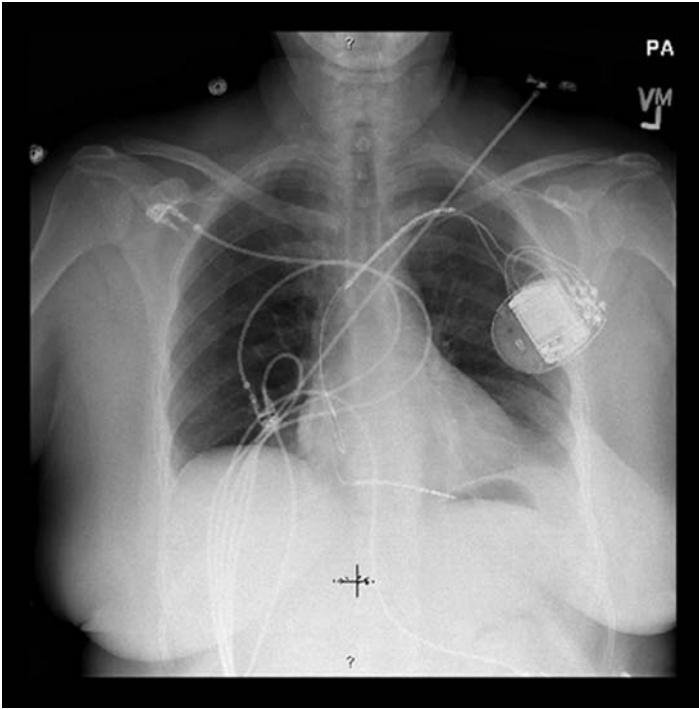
Chest X-ray of a typical dual-chamber ICD.
